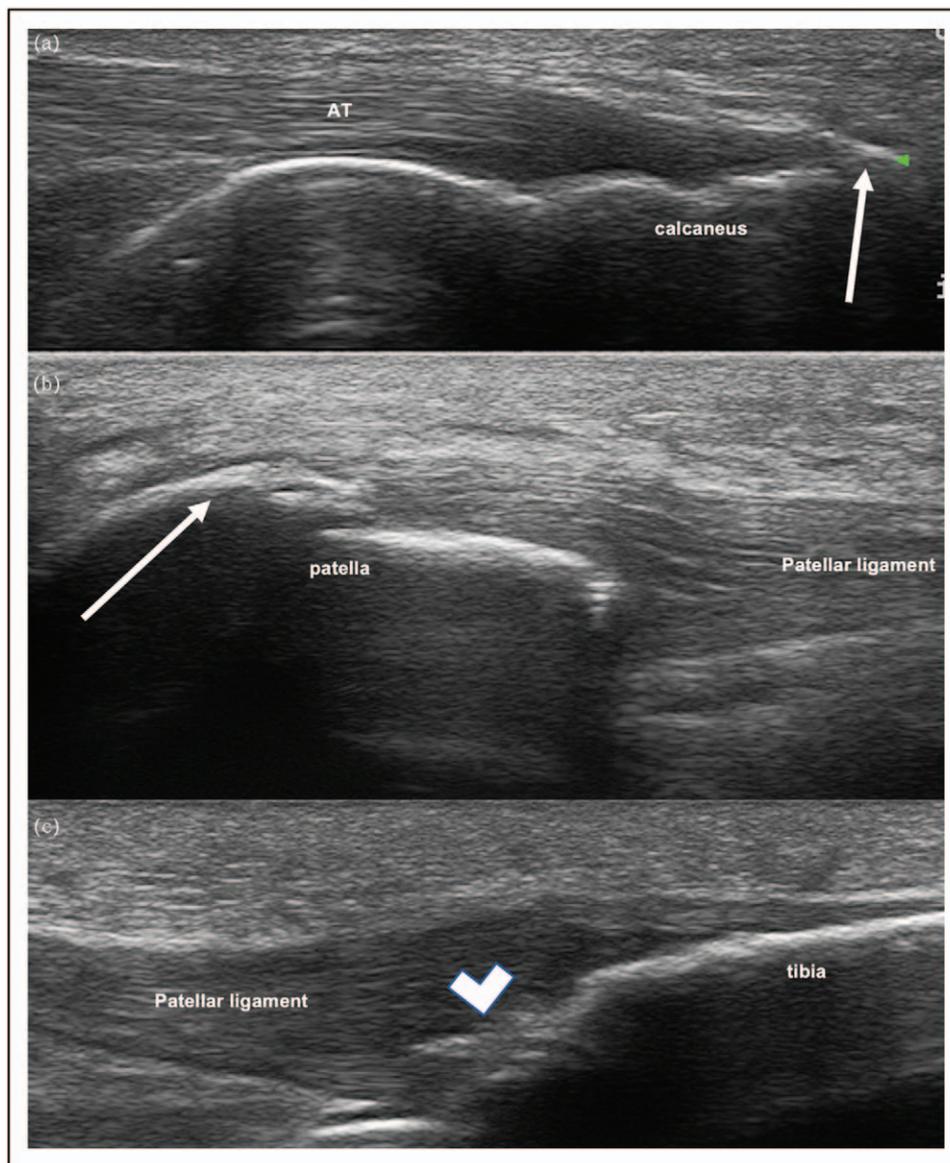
Enthesophytes in health and types of enthesophytes on ultrasound. (a) Longitudinal scan of the Achilles enthesis of a healthy person on ultrasound. A small enthesophyte is seen at the distal insertion (arrow) with no other disorders of the Achilles enthesis. AT, Achilles tendon. (b) Longitudinal scan of the Patellar ligament on ultrasound. Enthesophyte seen in the typical location at the border with increased tension at the origin of the patellar ligament (arrow). (c) Longitudinal scan of the Patellar ligament on ultrasound. Enthesophyte in the atypical location (arrow head), being in the middle of the enthesal insertion into the tibial tuberosity.
